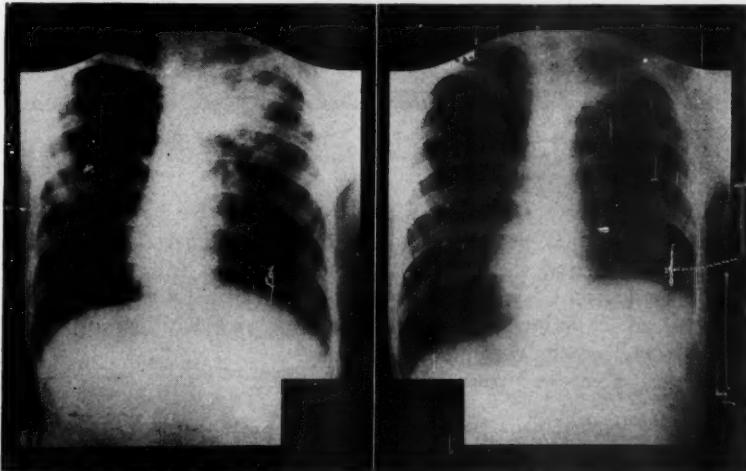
The x-ray on the right shows the rapid improvement in tuberculosis of the upper part of the right lung after interruption of the phrenic nerve. Note elevation of diaphragm.
